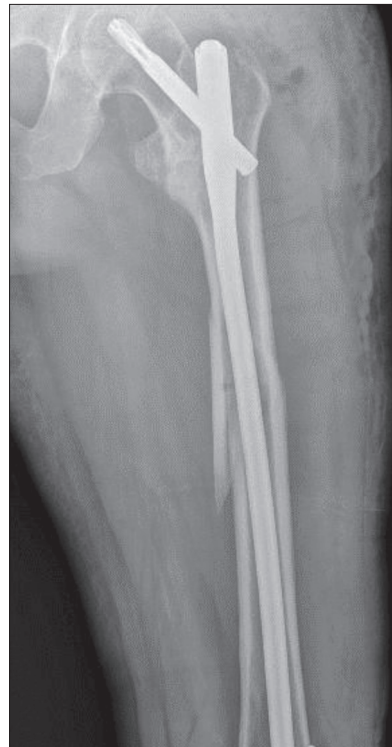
Radiography of the left hip and thigh on the first postoperative day [source: PACS Bežanijska Kosa UHMC]
